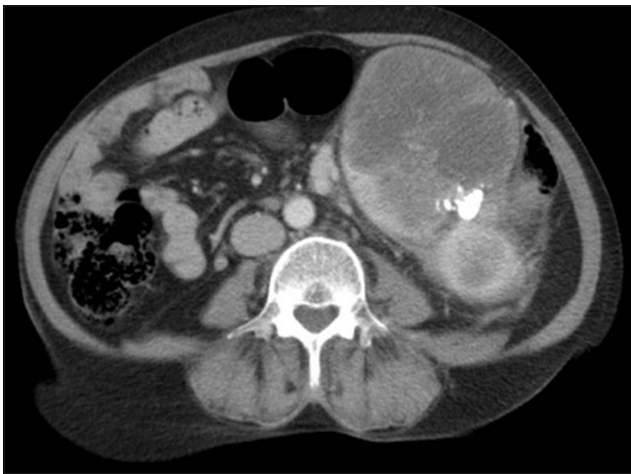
Contrast-enhanced computed tomography showing heterogeneously enhancing mass with calcification from left kidney
